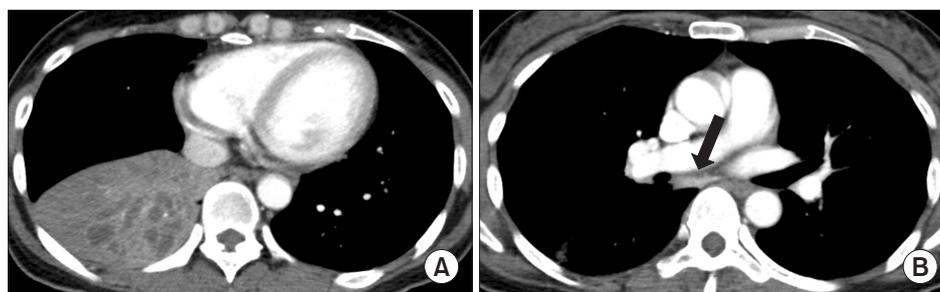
(A) An axial chest computed tomography (CT) image at the level of the left atrium shows lobar consolidation of the right lower lobe. Note the fluid bronchograms in the dilated bronchi. (B) An axial chest CT image at the level of the right bronchus intermedius shows a hypertrophied and well-enhancing subcarinal lymph node (arrow). Note this lymph node attaches to the right main bronchus.
